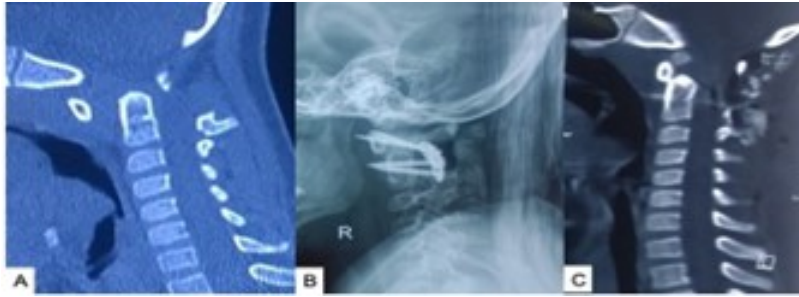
(A) CT scan of CVJ (sagittal view) showing AAD in 8-year-old boy with Down syndrome. (B) Postoperative plain X-ray of CVJ (lateral view) and (C) postoperative CT of CVJ (sagittal view) showing reduction, fixation, and fusion of AAD with lateral mass screws and plates and with facet joint fusion. Source: Figure by authors.
